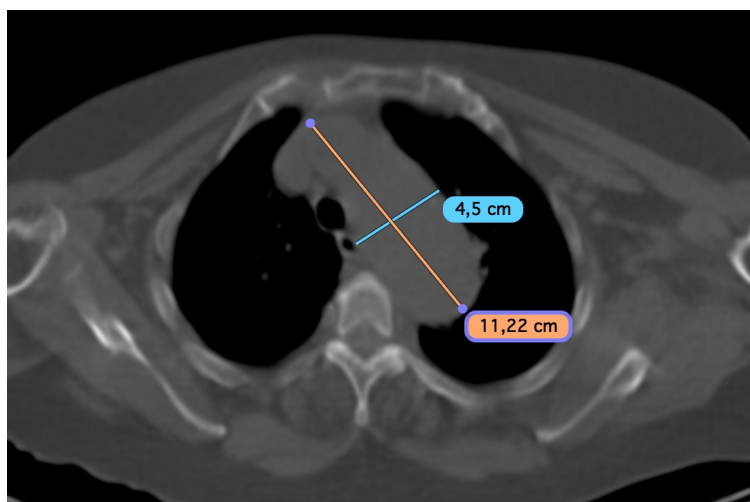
Axial CT angiographic image of the thoracic aorta showing the reported aortic wall abnormality associated with the Stanford type B intramural hematoma. Source-image caliper measurements are shown.
